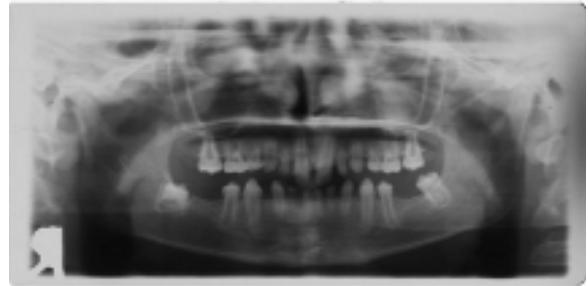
Panoramic radiography of Case 1, 19 permanent teeth are absent.
